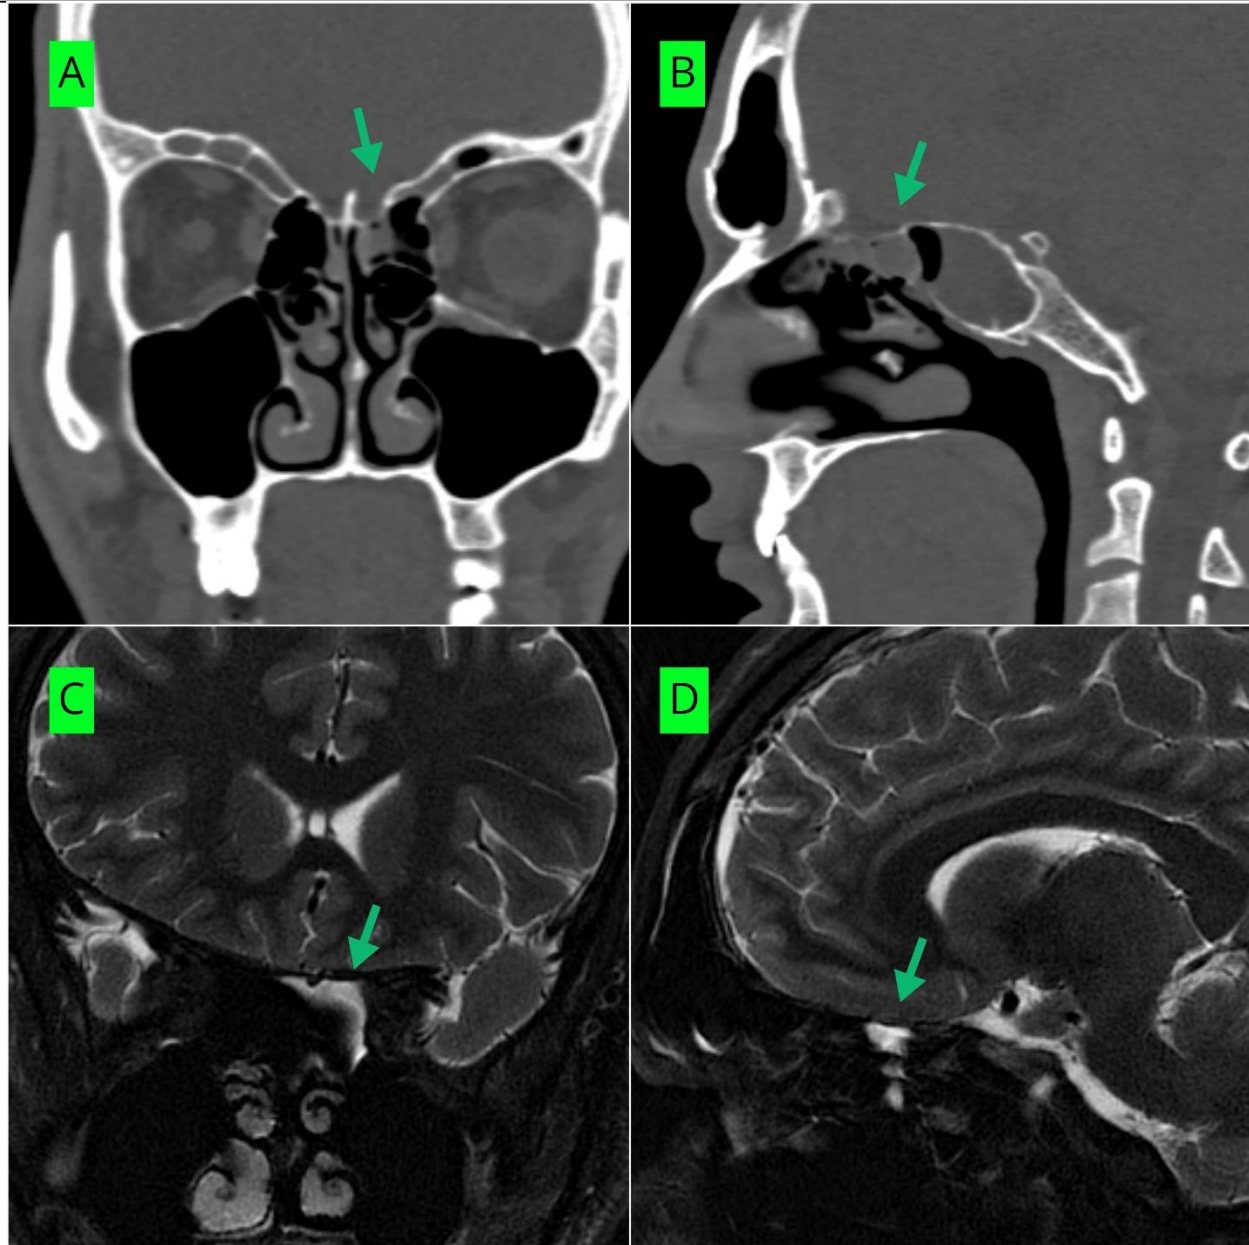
High-resolution CT and MRI demonstrating a post-traumatic anterior skull base defect with active CSF leak into the nasal cavity. Panels A (coronal) and B (sagittal) demonstrate the bony defect in the left half of the cribriform plate (green arrows). Panels C (coronal) and D (sagittal) show CSF leak into the nasal cavity (green arrows).
